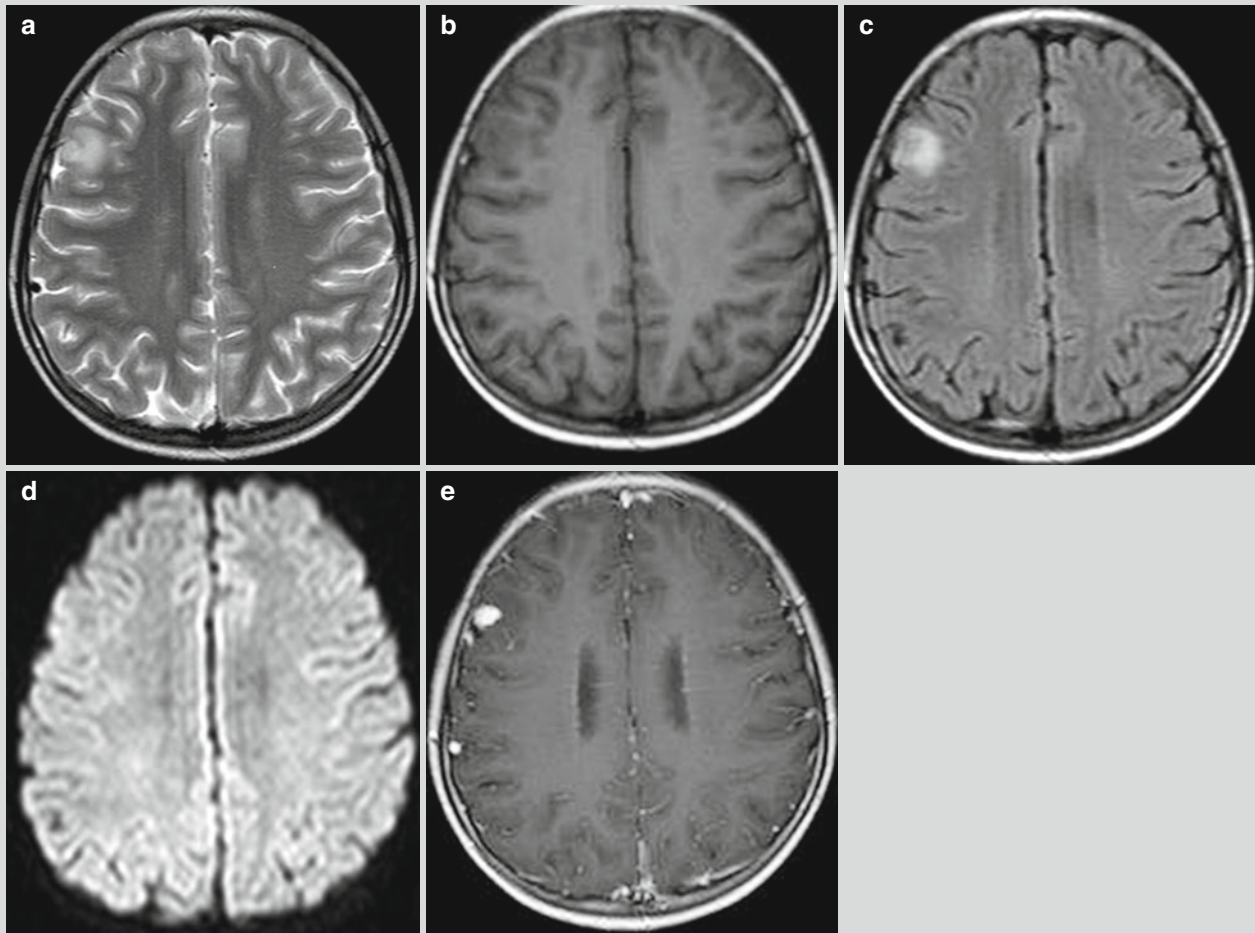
Tuberculous meningitis. (a–e) MR imaging demonstrates multiple nodular abnormal signal shadows at both brain hemispheres, with low T1WI signal and high T2WI signal. The water suppression
